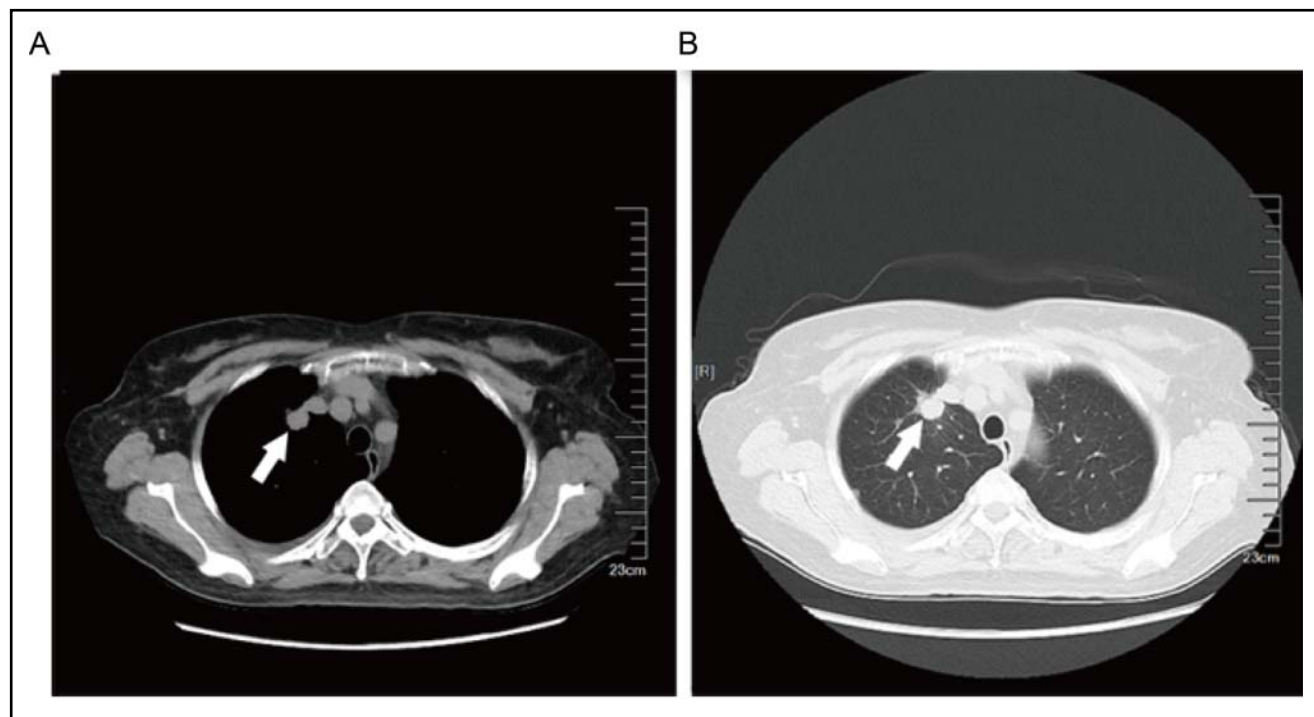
The results of lung CT. A. Lung CT mediastinal window, the arrow showed the location of the tumor. B. Lung CT lung window. The arrows showed the location of the tumor. CT: computed tomography.
